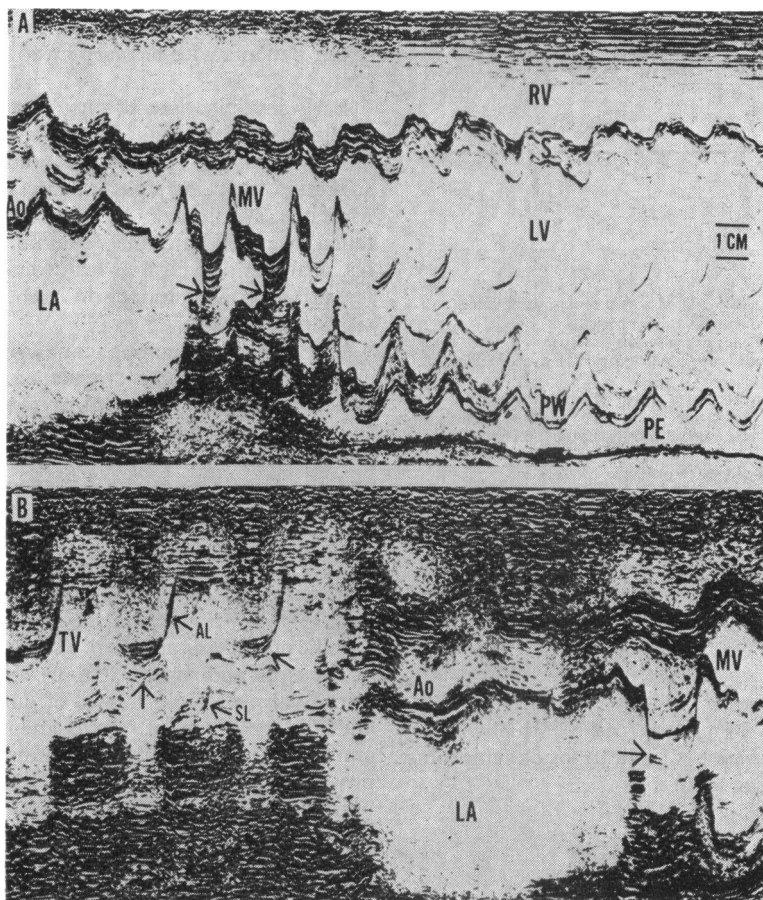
Patient with primary myxomatous degeneration of the mitral valve, mitral and tricuspid valve prolapse, and dilatation of the aortic root (case 2). (A) Echocardiographic "sweep" of the left ventricle from the base toward the apex. The mitral valve (MV) shows pronounced systolic prolapse (unlabelled arrows) and hypermobility of the prolapsing valve components. The left atrium (LA) is much enlarged as is the left ventricle (LV) and right ventricle (RV). There is a pericardial effusion (PE) seen posteriorly. PW, posterior wall; S, septum; Ao, aortic root. (B) Echocardiographic sweep (continuous recording) from the tricuspid valve (TV) through the aortic root (Ao) to the mitral valve (MV). There is an increased excursion of the anterior (AL) and septal leaflets (SL) as well as systolic prolapse of both anterior and septal leaflets. A hypermobile portion of the mitral valve (unlabelled arrow) is also seen prolapsing back towards the left atrium (LA) as in (A).
